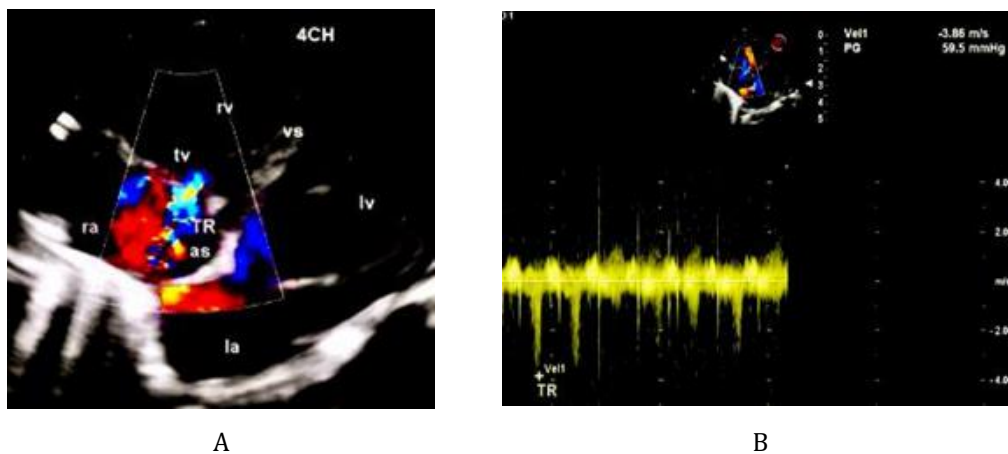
(A) 4 CH View. Mild tricuspid regurgitation (TR) is observed. tv; tricuspid valve, vs; ventricular septum, as ; atrial septum. (B) On continuous wave doppler (CWD) analysis across the tricuspid valve a TR velocity of 3.85 m/sec (gradient 59.5 mmhg) is delineated
